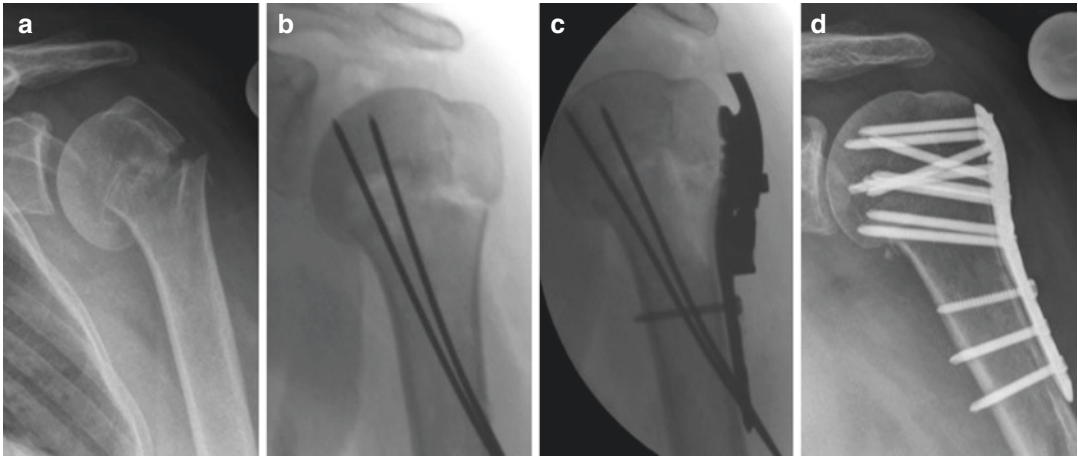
(a) Radiograph of a varus displaced 2-part surgical neck fracture of a 35 y.o. female. (b) Reduction of the head fragment and preliminary fixation to the shaft with two previously introduced intramedullary K-wires
